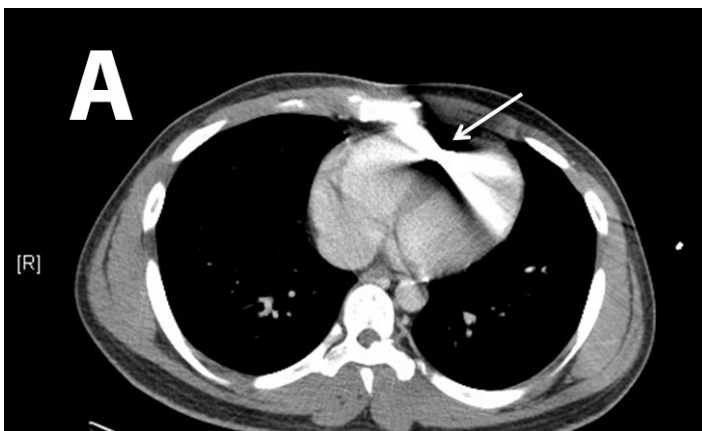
Chest computed tomograph showing bullet (arrow) in the right ventricle, both transverse (Figure 2a) and sagittal (Figure 2b) views showing significant glare.
